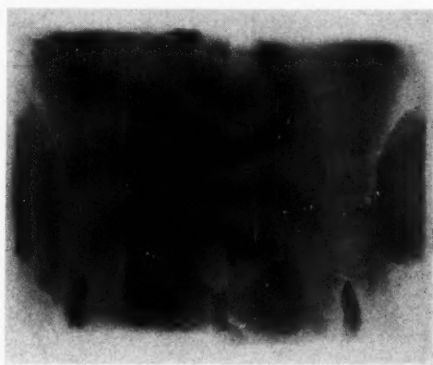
Roentgenograms of both treatment fields on the same film. A cotton plug soaked in barium lies in the vaginal vault, showing that all the paracervical area and the upper two thirds of the vagina are included. A comparison with Figure 1 shows that all primary nodes are included. The dark streak down the center is the crossing of the fields.
